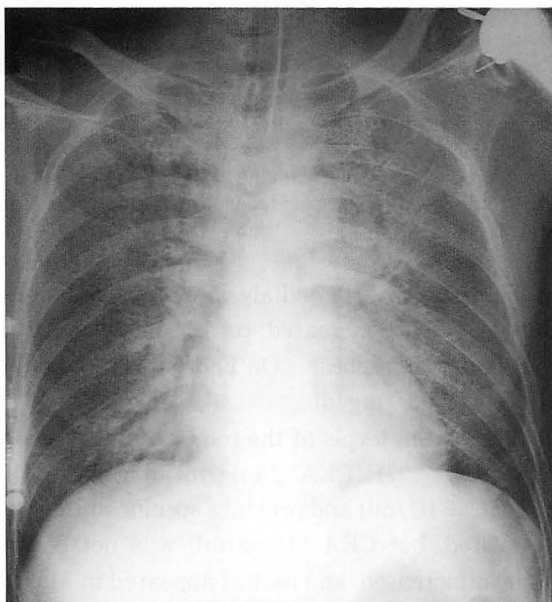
Roentgenogram of the patient taken on August 10, 2000. Interstitial lung lesions are visible throughout both lung fields.
